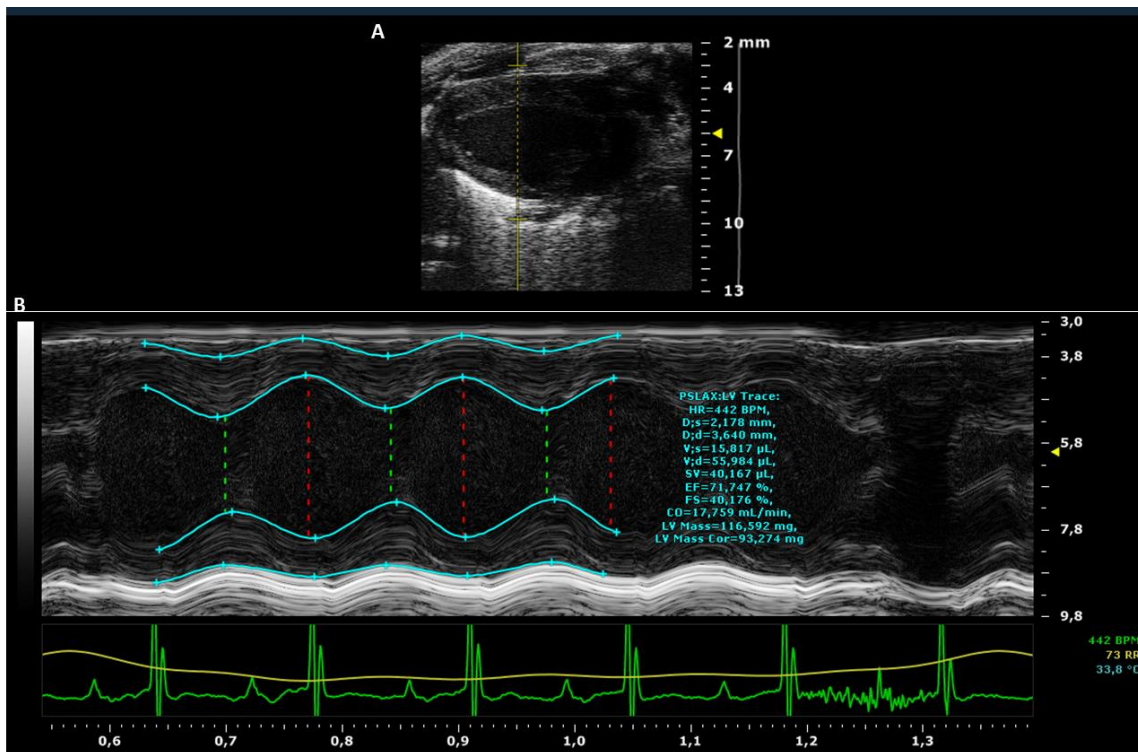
Echocardiographic image recoding and cardiac systolic function analysis
